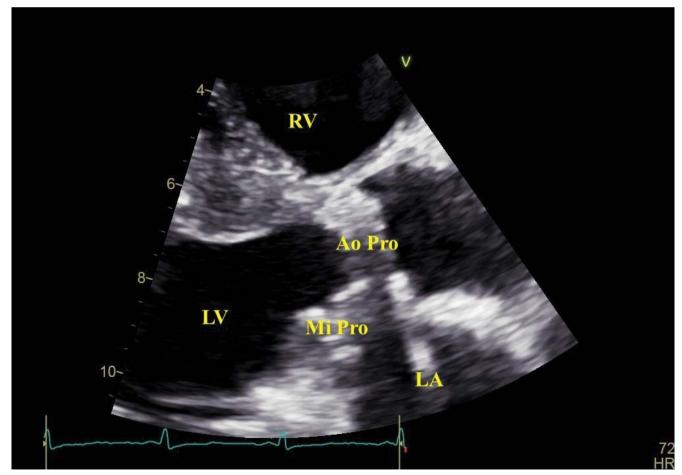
Transthoracic echocardiography, parasternal long axis view, zoom on the aortic and mitral prosthesis. Structural changes of the mitral prosthesis suggestive of possible thrombosis. No significant changes seen on the aortic prosthesis. Ao Pro, aortic prothesis; LA, left atrium; LV, left ventricle; Mi Pro, mitral prosthesis; RV, right ventricle.
